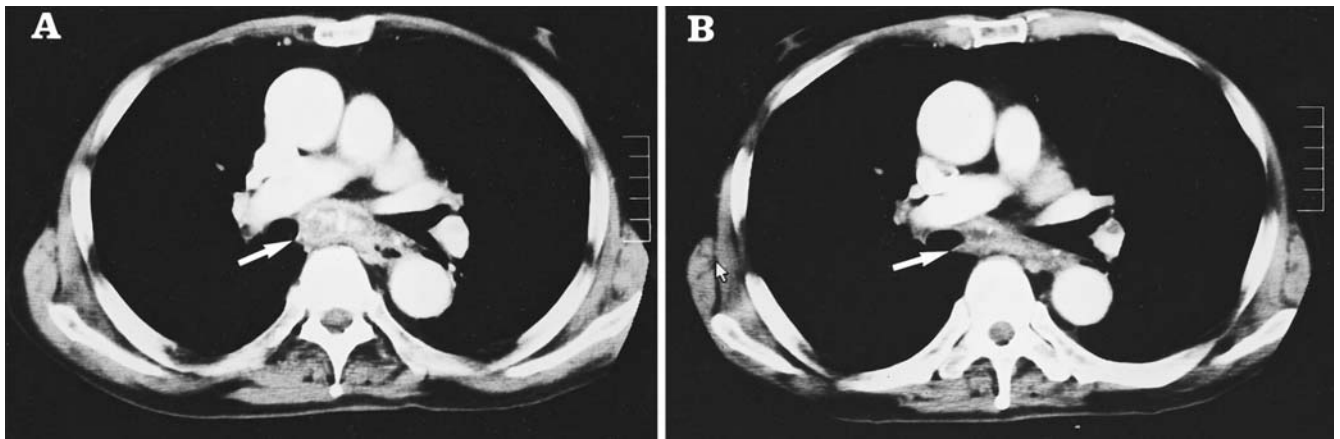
Findings of chest CT. A Finding on July 28, 2000. B Finding on August 30, 2000, 2 weeks after the initiation of treatment. Chest CT revealed that the subcarinal lymph nodes were markedly reduced in size. *Arrows* show the subcarinal lymph nodes
